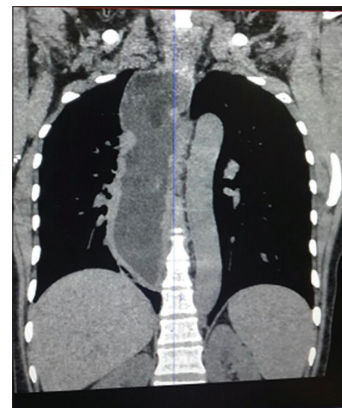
Mediastinal opacity on computed tomography
